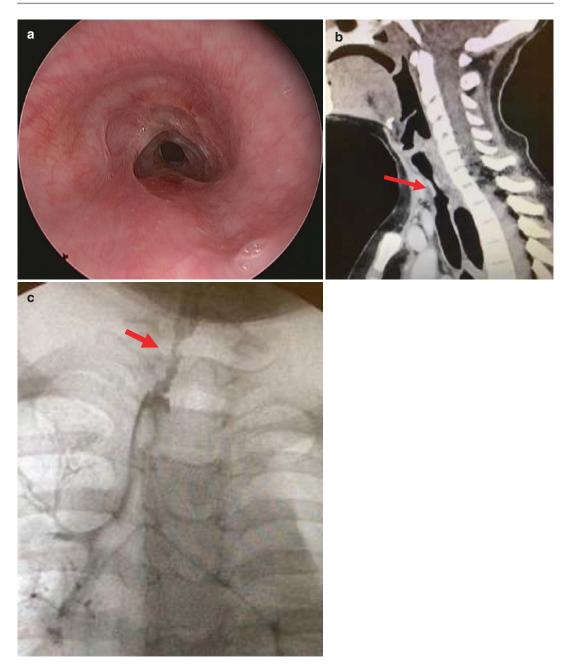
(a) Post-intubation tracheal stenosis. Rigid endoscopy view. (b) Post-intubation tracheal stenosis CT scan. Tracheal stenosis segment (red arrow). (c) Postintubation tracheal stenosis. Tracheobronchography.
